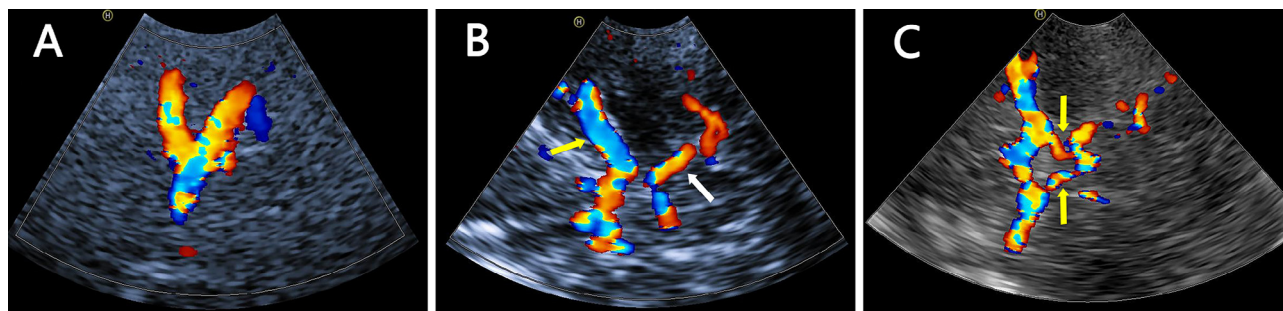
TCCS image of normal BA, IVA, PCA and opening posterior communicating artery. (a) TCCS reveals the Y shape of normal BA and the bilateral side of the IVAs. (b) TCCS reveals the MCA (yellow arrow) and PCA (white arrow) through temporal windows. (c) TCCS reveals the bilateral side of the opening posterior communicating artery (yellow arrow). TCCS = transcranial color-coded sonography; BA = basilar artery; IVA = intracranial vertebral artery; PCA = posterior cerebral artery; MCA = middle cerebral artery.
